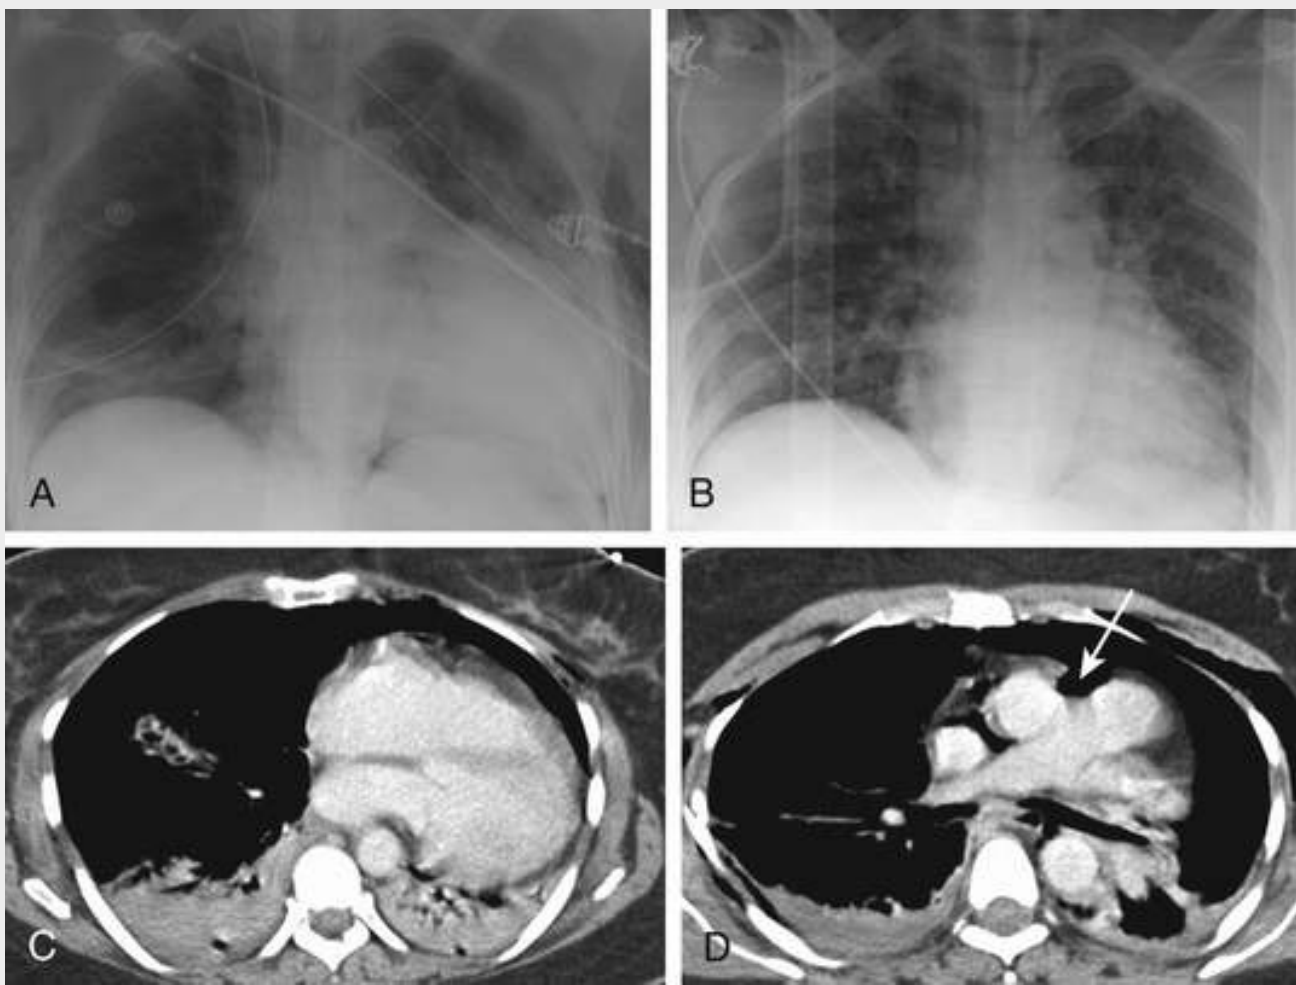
Partial absence of the pericardium. A, Portable AP chest radiograph of patient with multiple injuries from a motor vehicle accident shows leftward rotation of the heart (patient not rotated during imaging). B, AP radiograph obtained 4 hours earlier shows normal appearance of the heart, indicating that this is an acquired absence of the pericardium, with the heart herniating through the defect. CT images at the level of the ventricle (C) and the upper mediastinum (D) show marked leftward rotation of the heart, such that it drapes over the descending aorta (C), and no pericardium covering the space between the ascending aorta and the main pulmonary artery, allowing the lung to extend into that space (*arrow*).
